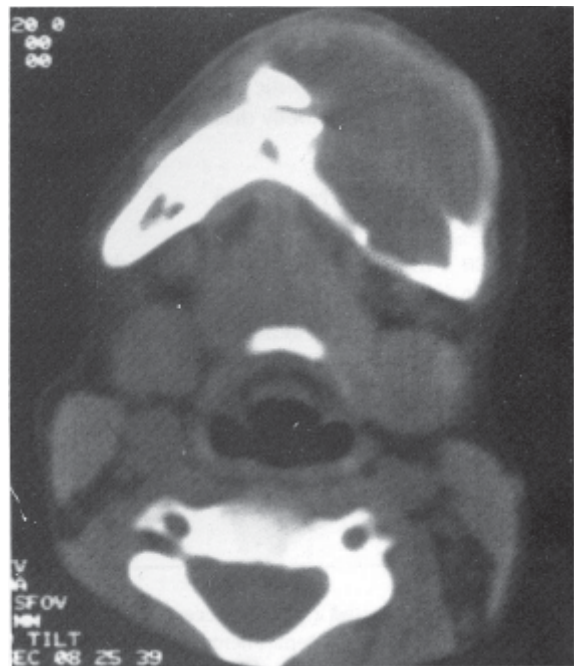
CT scan of the mandible showing bucco-labial extension of the cystic lesion.
